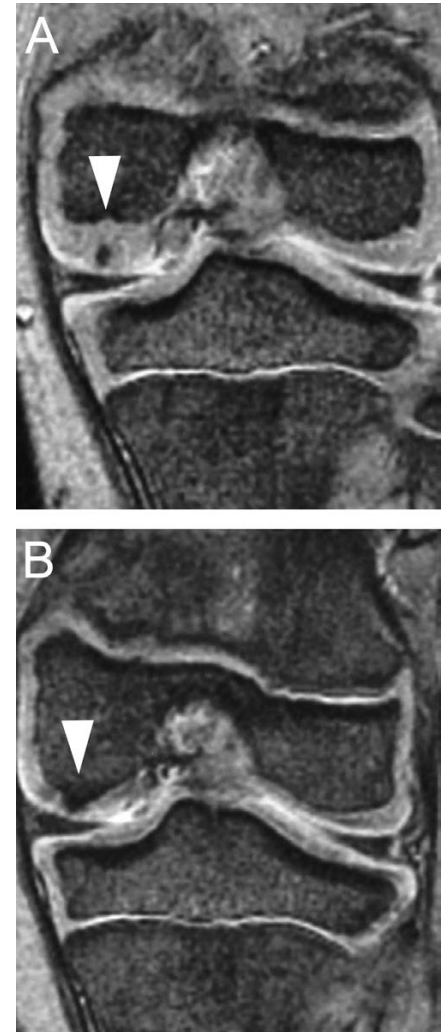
Coronal plain T2-weighted magnetic resonance imaging of the left knee. (A) At the 2nd visit to our outpatient clinic, a low signal intensity spot is detected within the articular cartilage (white arrowhead). (B) 18 months after Figure 2-A, the low signal intensity spot is united with medial femoral condyle (white arrowhead).
